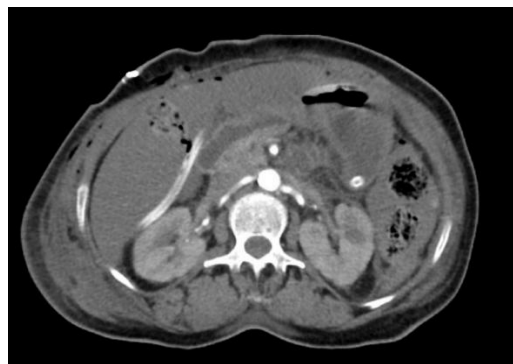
Abdominal CT without showed a diffuse colonic edematous wall with a decreased enhancement, not suggesting post-operative changes/ischemia.
